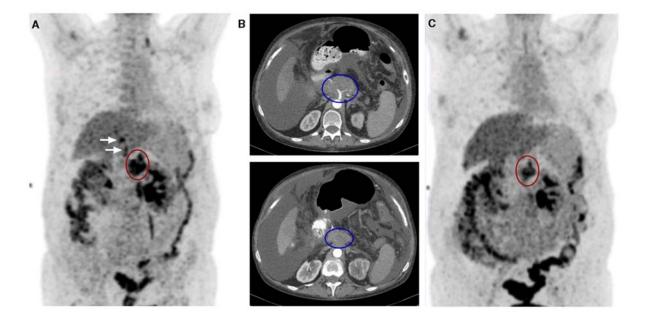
¹⁸FDG PET and CT scans of patient 3 before (A, B) and after (C, D) ¹⁷⁷Lu-3BP-227 therapy. (A) ¹⁸FDG PET before ¹⁷⁷Lu-3BP-227 therapy. Red oval: primary tumor. Arrows: liver metastases. (B) Upper panel: Axial CT section; primary tumor (blue oval) before ¹⁷⁷Lu-3BP-227 therapy. Lower panel: Axial CT section; primary tumor (blue oval) after three cycles of ¹⁷⁷Lu-3BP-227 therapy. (D) ¹⁸FDG PET after three cycles of ¹⁷⁷Lu-3BP-227 therapy. (D) ¹⁸FDG PET
